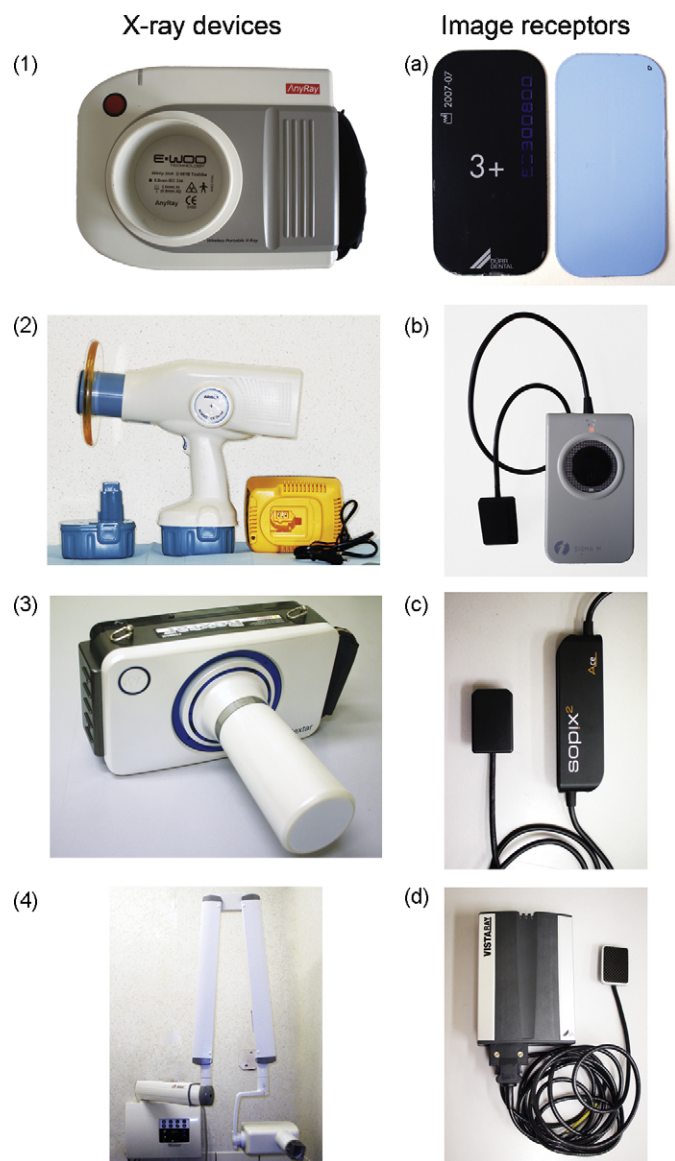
In the present study, four X-ray devices: AnyRay[®] (1), Nomad[®] (2), Rextar[®] (3) and MinRay[®] (4) were evaluated together with four image receptors: Dürr PSP[®] (a), Sigma[®] M CMOS (b), Sopix²[®] CMOS (c) and VistaRay[®] CCD (d).
